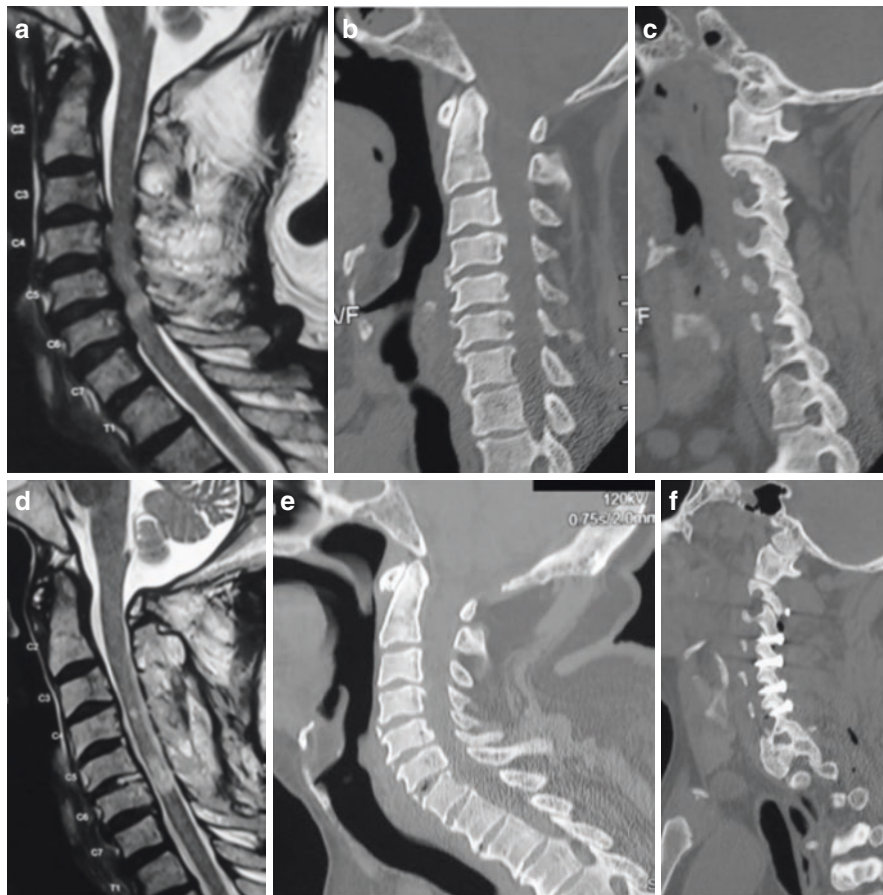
Images a 65-year-old male patient showing fixation using transarticular facet fixation. (a) T2-weighted MRI showing evidence of significant multi-level spondylotic disease with cord compression. (b) CT scan showing degenerative changes in the spine. (c) Sagittal section showing the facets. (d) Postoperative MRI showing reduction in the extent of cord compression. (e) Postoperative CT showing no bone decompression. (f) Sagittal section through the facets showing C2–7 transarticular screw fixation
